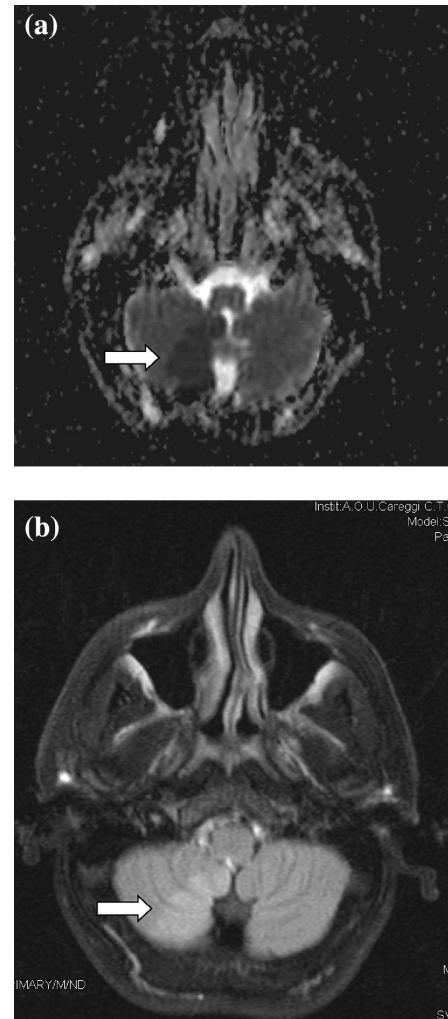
(a) Brain DWI-MR showing a right cerebellar ischaemic lesion in the PICA territory (white arrow). (b) Brain T2 sequences MRI showing the same lesion.
